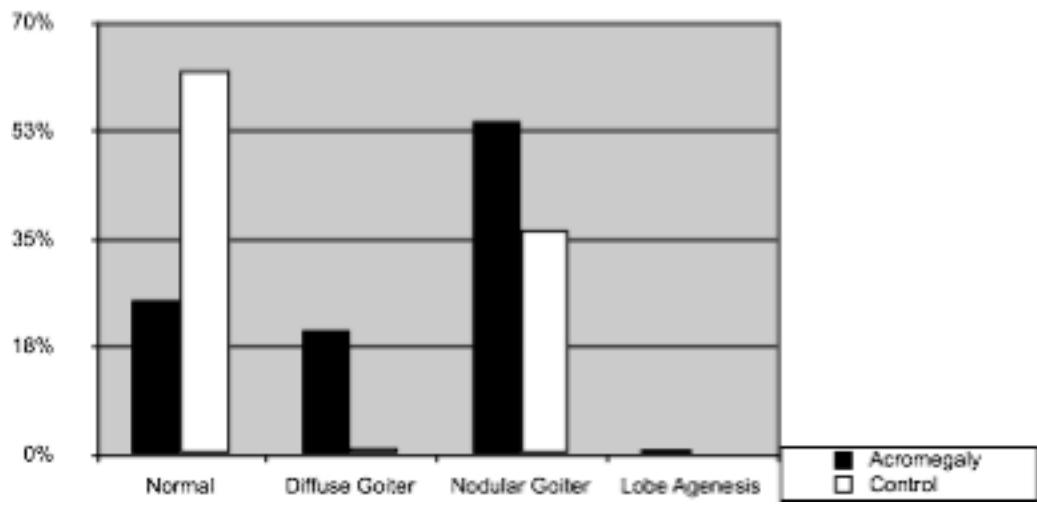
Thyroid ultrasonography findings (n=387)
